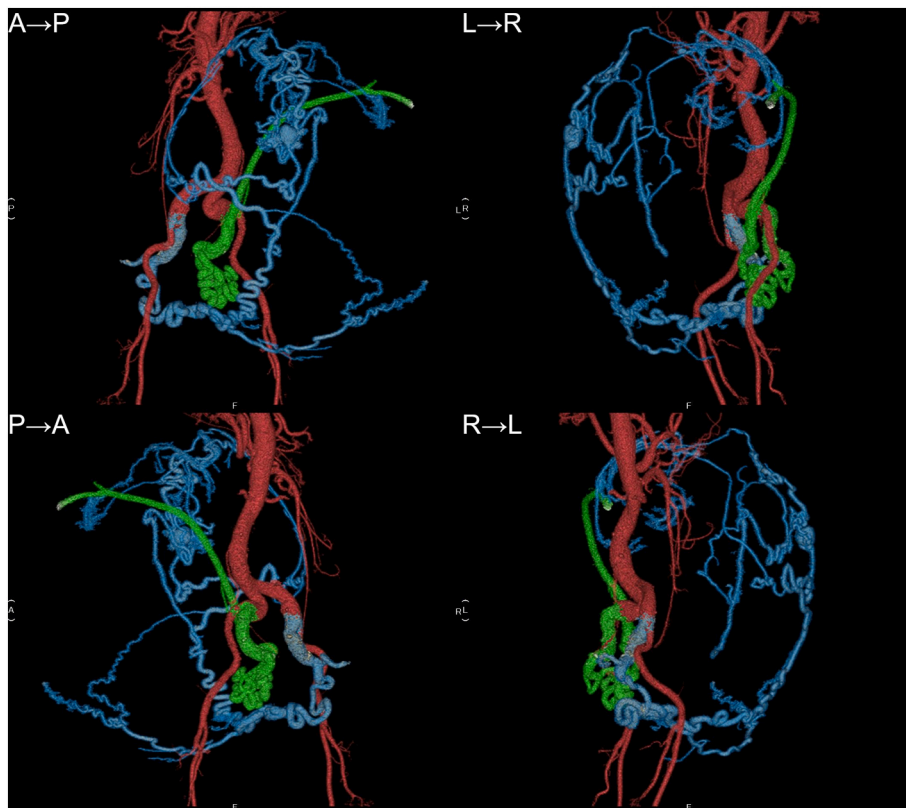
Three-dimensional computed tomographic depiction of tumor feeding vessels. The distribution from the bilateral uterine arteries was confirmed. Blue vessels represent the right internal iliac artery system; green vessels represent the left internal iliac vascular system. A → P, anteroposterior image; P → A, posteroanterior image; L → R; left-to-right image; R → L; right-to-left image.
